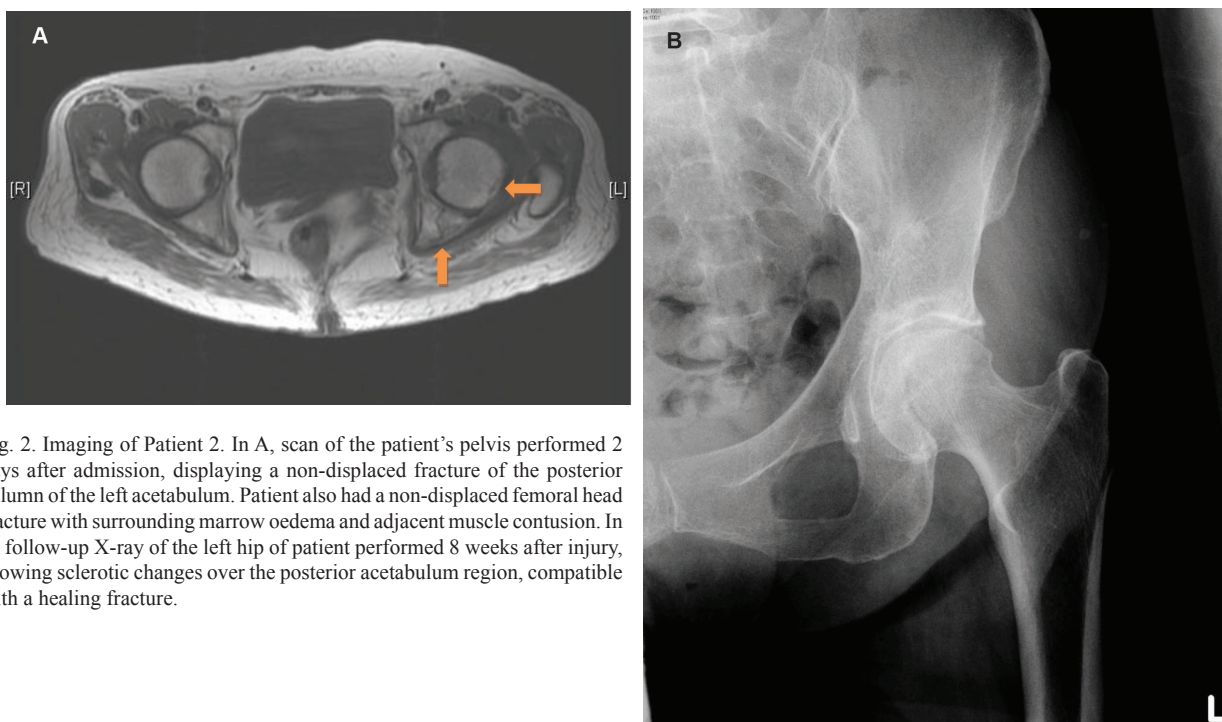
Imaging of Patient 2. In A, scan of the patient's pelvis performed 2 days after admission, displaying a non-displaced fracture of the posterior column of the left acetabulum. Patient also had a non-displaced femoral head fracture with surrounding marrow oedema and adjacent muscle contusion. In B, follow-up X-ray of the left hip of patient performed 8 weeks after injury, showing sclerotic changes over the posterior acetabulum region, compatible with a healing fracture.
